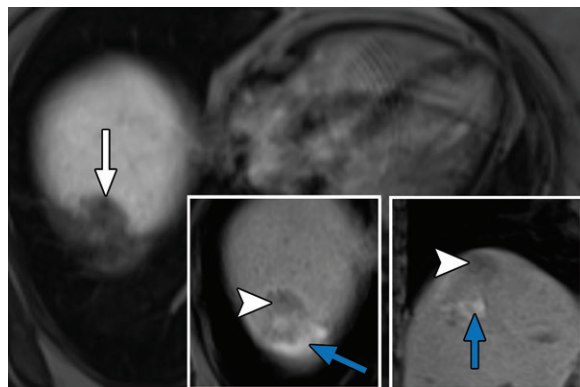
Postablation HBP imaging in a 56-year-old woman with metastatic rectal cancer after microwave ablation of a hepatic metastasis. Axial T1-weighted HBP image with gadoxetate shows hypointensity (white arrow) of an ablated segment VII liver dome metastasis. Nonviable ablated tissue is difficult to distinguish from viable tumor. Local recurrence can be more easily identified on the axial (left inset) and coronal (right inset) T1-weighted precontrast MR images, which show hypointensity of recurrent tumor (white arrowheads) adjacent to the intrinsically T1-hyperintense ablation zone (blue arrows).
